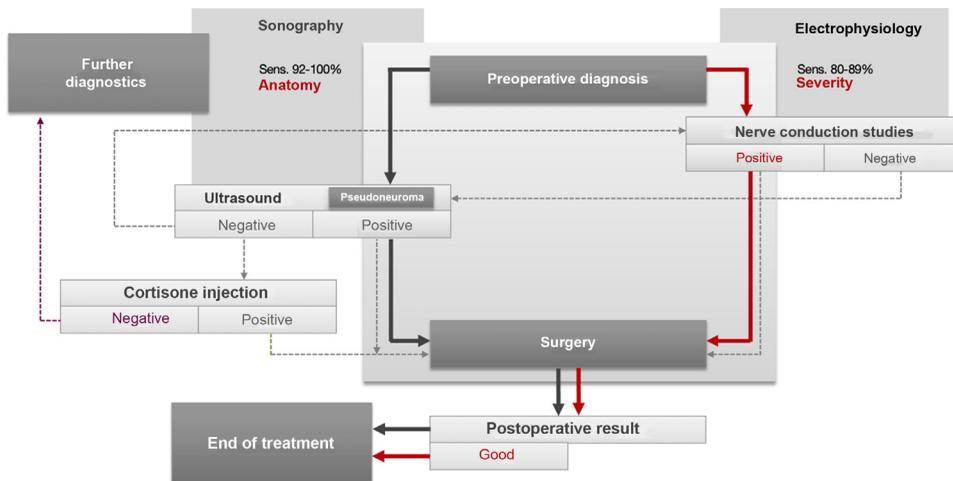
Comparison between sonography and electroneurography—Preoperative workflow. While electrodiagnostic testing can diagnose carpal tunnel syndrome with a sensitivity of 80% to 89%, the sensitivity of sonography is about 92% to 100%. Electrodiagnostic testing basically allows statements to be made about the severity of the disease (*right*), whereas sonography focuses primarily on quantitative and semiquantitative parameters (*left*). In the case of negative findings in either electrophysiology or sonography, both examination modalities can complement each other. In the case of negative findings on both sides, diagnostic steroid infiltration can help to confirm the diagnosis, which is also possible under sonographic guidance.
